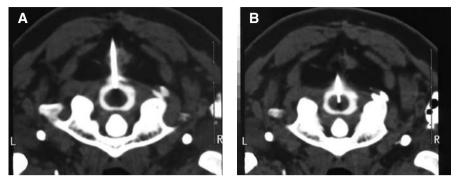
A Final position of the cannula in axial CT slices in EM. B Final position of the electrode in axial CT slices, occiput- C_1 level, in EM
